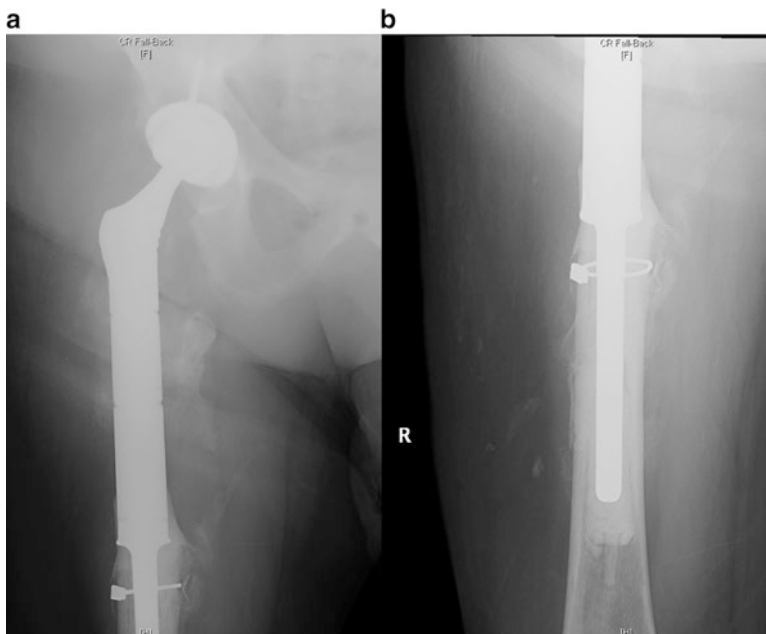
AP and lateral radiographs of the right hip and femur demonstrating definitive reconstruction using a cemented, segmented, proximal femoral replacement megaprosthesis
